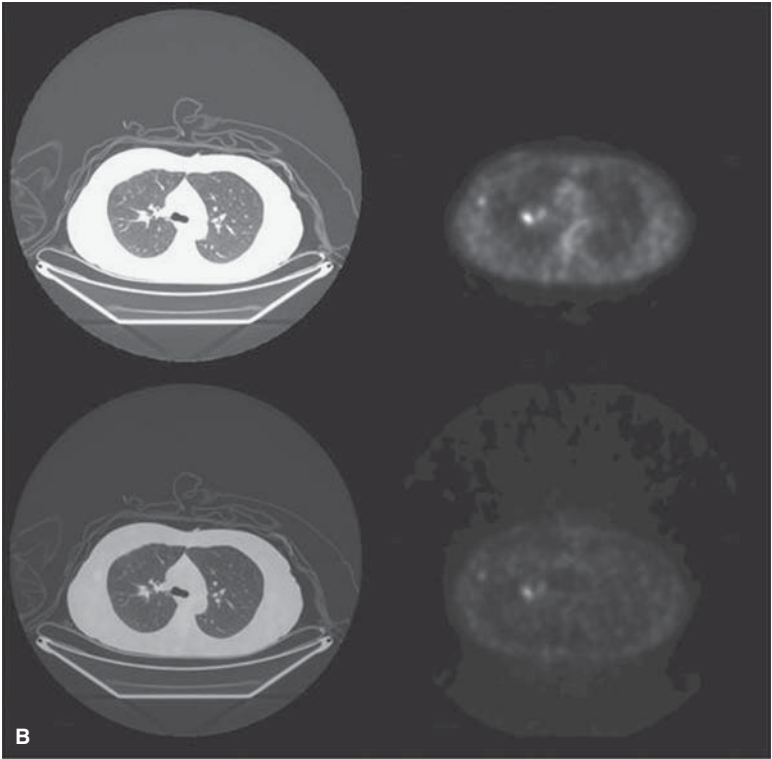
Continued.* (B) Transaxial images of the chest demonstrate a lung metastasis (not obvious on CT) as well as hilar nodal metastases. The upper left image is the CT with lung windows, upper right is the attenuation-corrected PET image, the lower left is the fusion image, and the lower right is the non-attenuation-corrected PET image.
